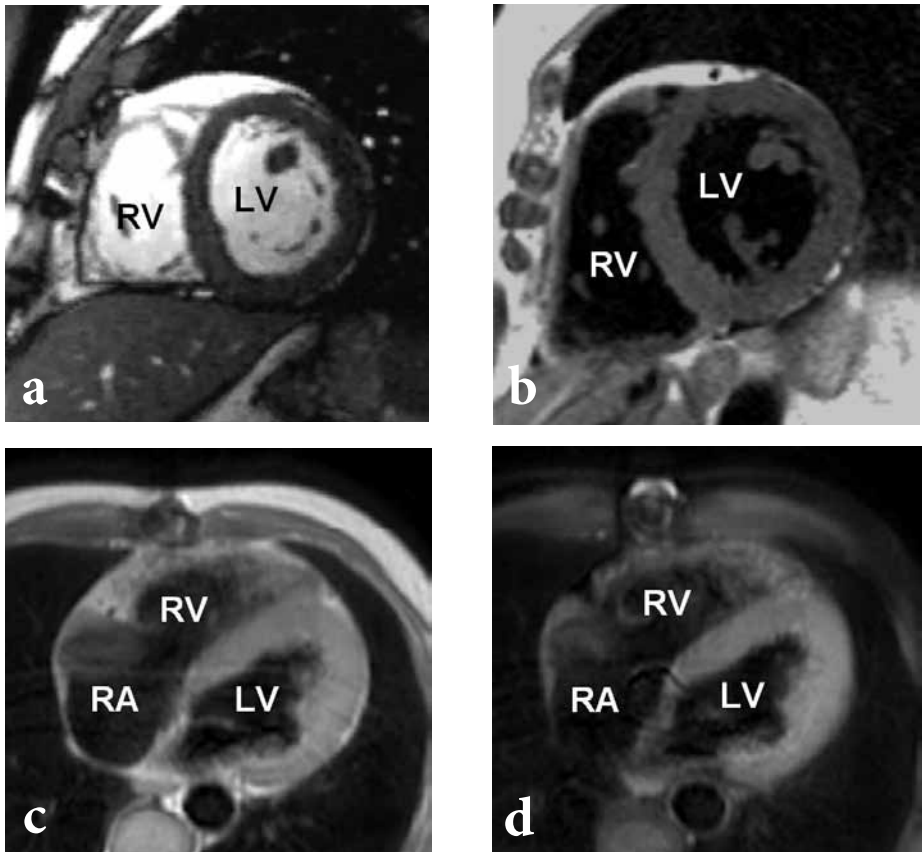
(a) bSSFP short-axis image with high blood signal intensity; (b) T1-weighted black blood short-axis image showing clear endocardial borders; (c) transverse T1-weighted black blood image without fat saturation; (d) transverse T1-weighted black blood image with fat saturation. LV = left ventricle; RV = right ventricle; RA = right atrium.
